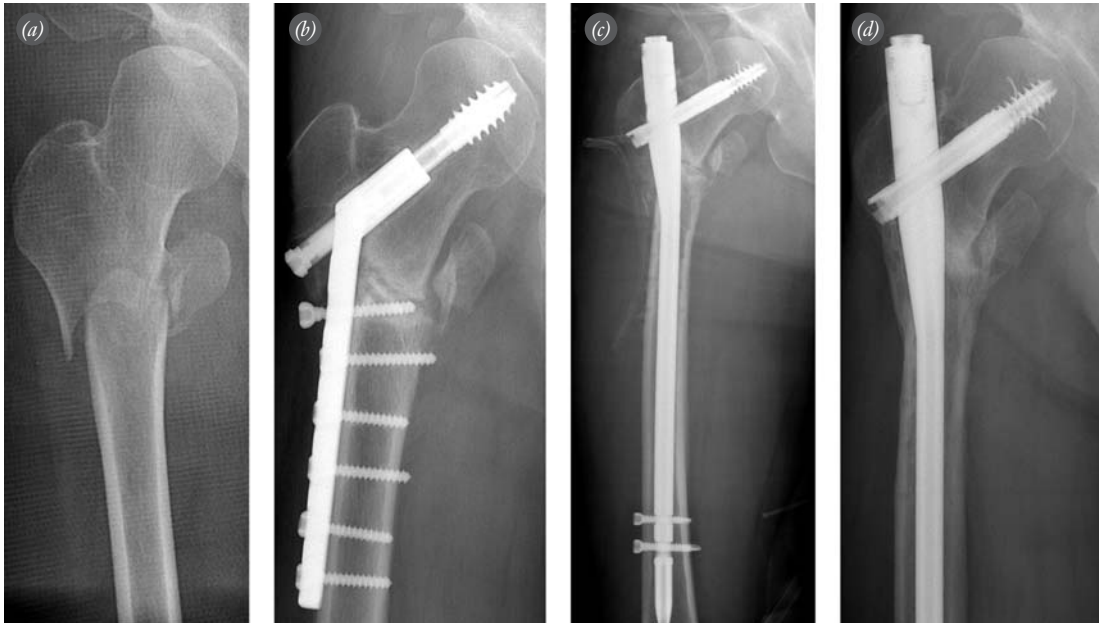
Antero-posterior view of a subtrochanteric fracture (a) in a 44-year-old male patient involved in a traffic-accident. Antero-posterior radiograph (b) shows atrophic nonunion 11 months after internal fixation with a CHS. (c) CHS was removed and a cephalomedullary nail was applied with autogenous bone graft. (d) Radiograph shows a union 6 months after the revision.
